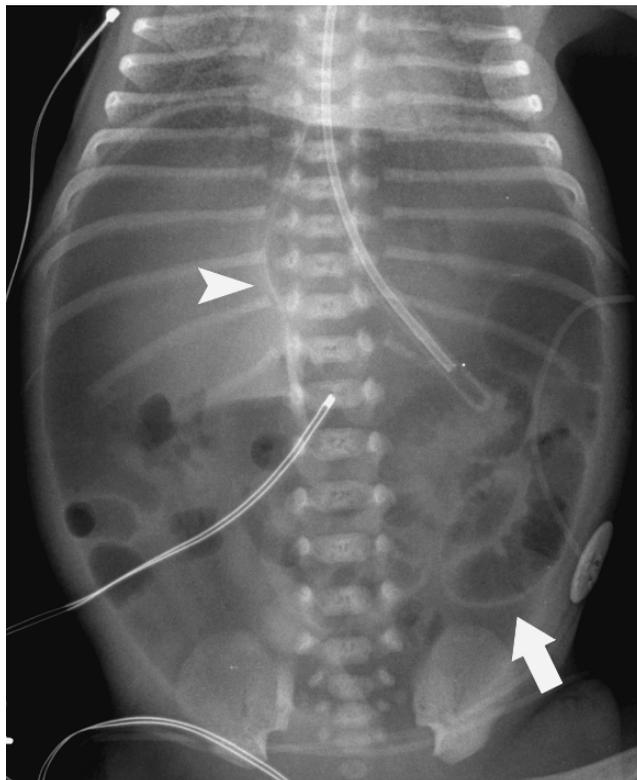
Pneumoperitoneum. Massive pneumoperitoneum on supine radiograph. Free air outlines the falciform ligament (arrowhead) and is seen on both sides of the bowel wall (arrow).
